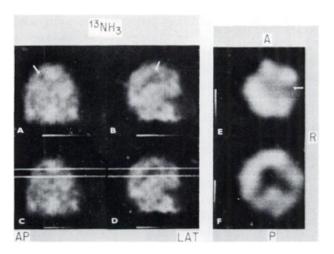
Positron scintigrams taken with ¹⁸NH₃ in 64-year-old man with glioma. (A,B) AP and LAT views; (C,D) images A and B shown with lines separated by 3 cm representing positions of two reconstructed tomograms shown in E and F. (E,F) Tomograms reconstructed from 23 views taken around subject after intravenous administration of ¹⁸NH₃. Correction for attenuation was applied. Linear scanning motion was not applied.
